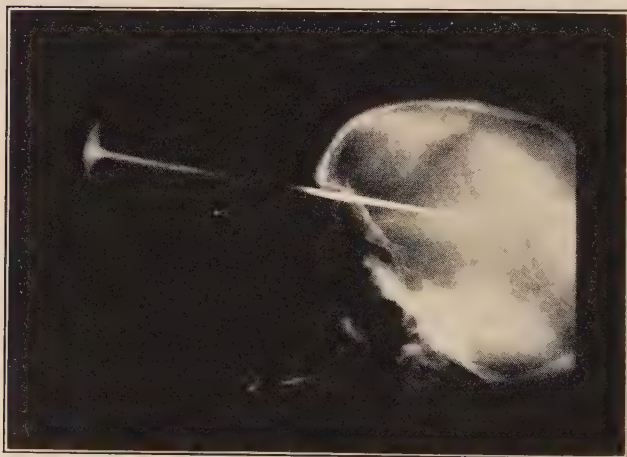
X-ray after deep frontal cut.
